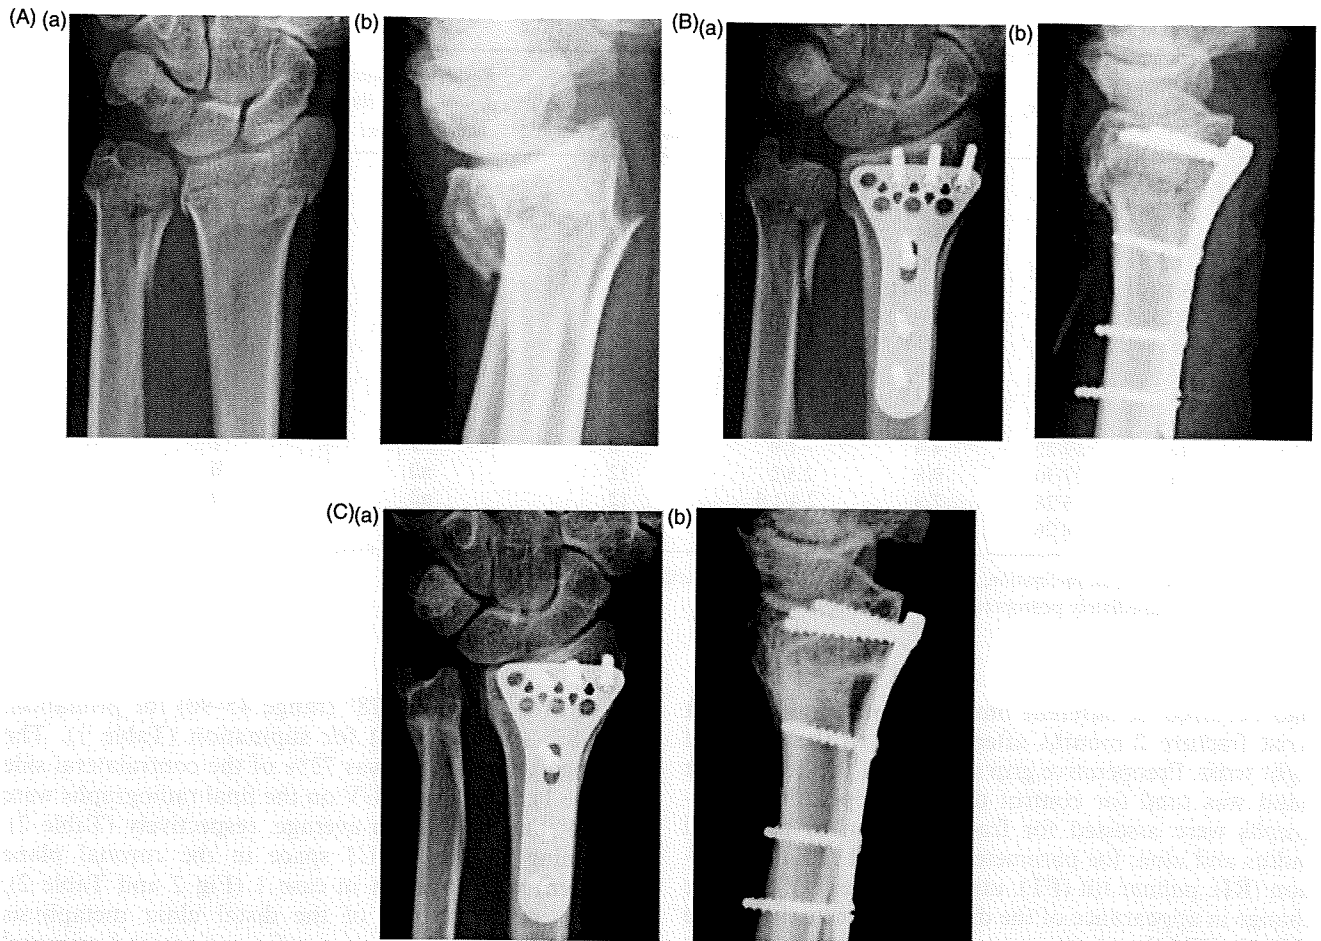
Radiograph of the wrist (case 1). (A) Initial radiograph of the wrist. (B) Radiograph immediately after operation. (C) Final radiograph. All radiographs show (a) anteroposterior and (b) lateral view. The widening of the DRUJ space was apparently due to atrophy of the distal ulnar metaphysis.
